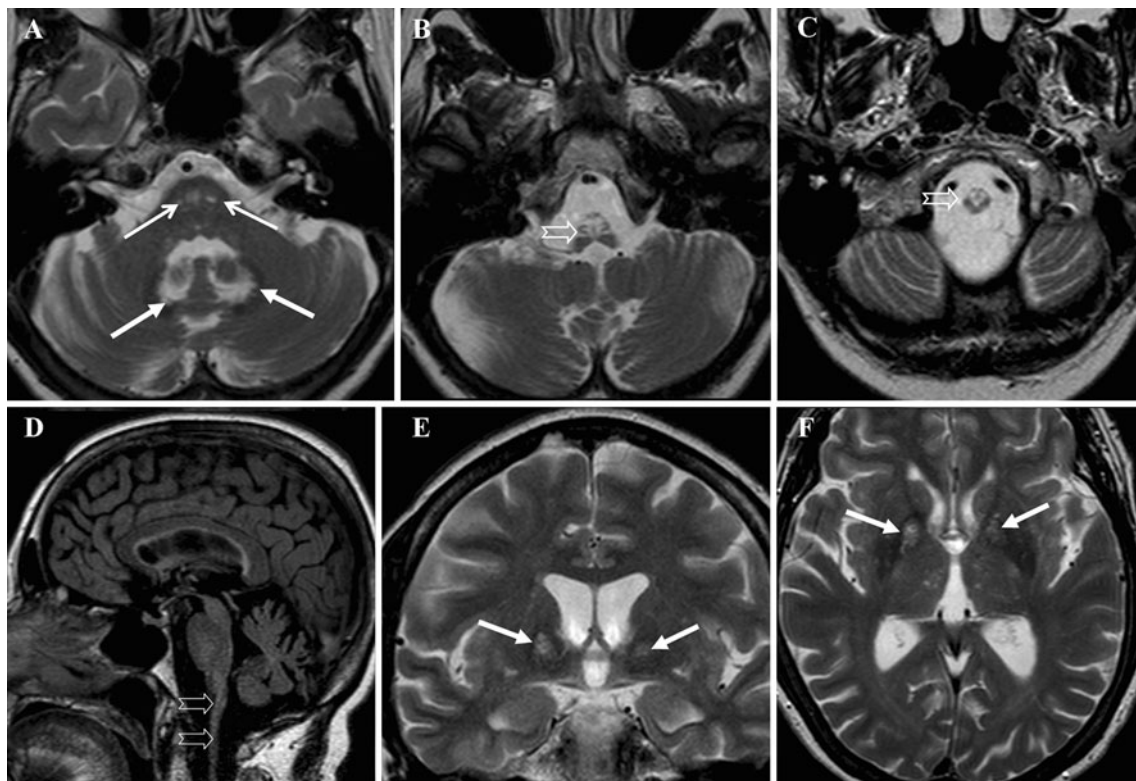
MRI findings in a 65 year old woman with a novel missense mutation (c. 1148C > T, p. T383I) in the *GFAP* gene. The details are outlined in the text
